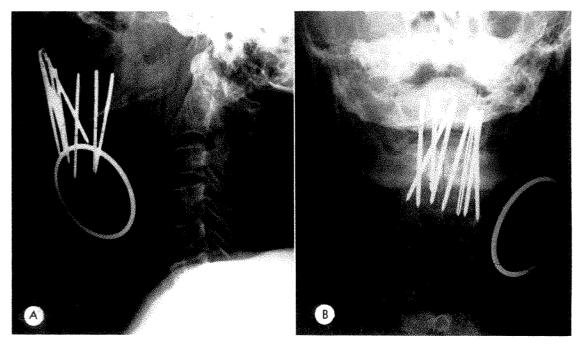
(A) Lateral and (B) anteroposterior roentgenograms of an interstitial radium implant of the lateral border of the tongue. The implant is composed of 8 Indian-club needles, 1.66 mg. radium each, 4.0 cml active length, 0.65 mm. platinum filtration.
